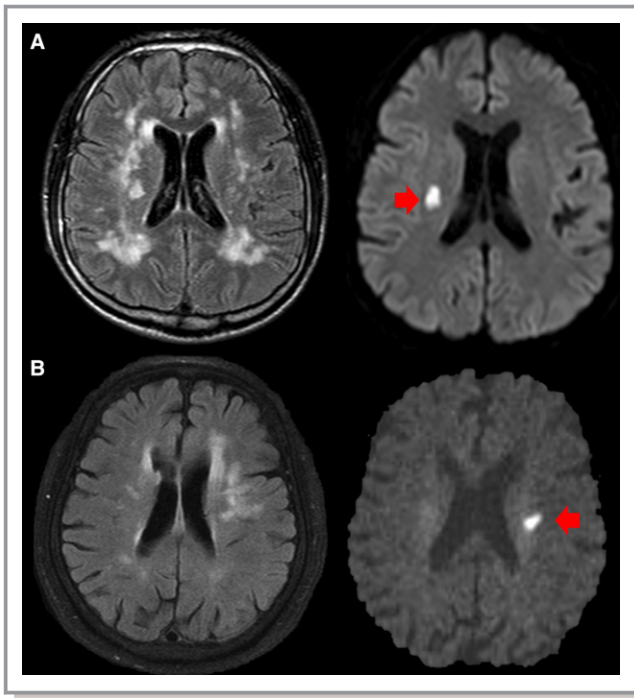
Representative cases of asymmetric white matter hyperintensity (WMH) versus acute lacunar infarct. Two cases (A and B) show the association between the hemispheric dominance of WMH on fluid-attenuated inversion recovery magnetic resonance imaging (left column) and hemispheric predilection site of an acute lacunar infarct on diffusion-weighted imaging (arrows in the right column).
